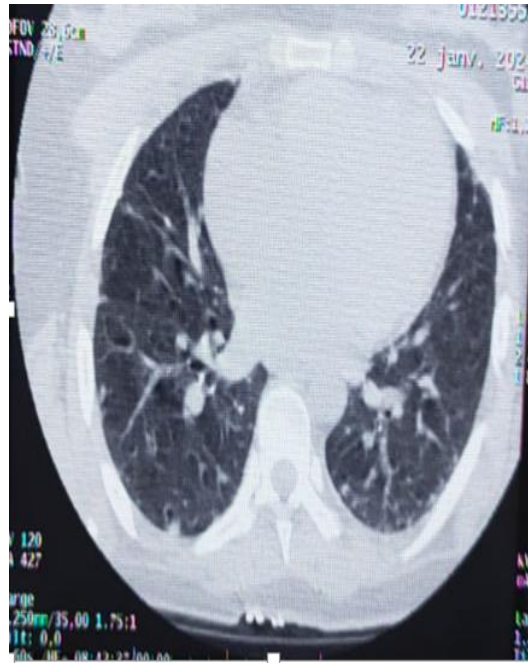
CT scan 1 month after Antimicrobial therapy showing the reduction in the size of the nodules , 7 mm for the right apical nodule , and 8 mm for the left postero-basal
